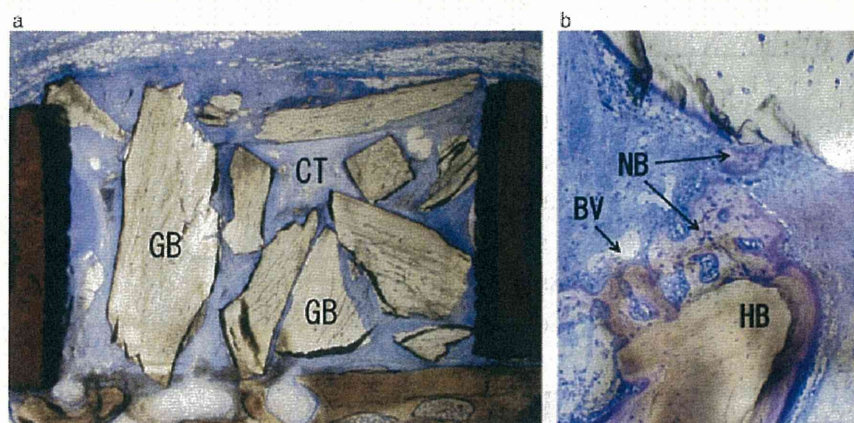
Large bone grafted site at 2 weeks. (a) Grafted bone (GB) almost preserved its original shape. In the interspace of the GB, fibrous connective tissue (CT) was observed. Magnification $\times 2.5$. (b) High-magnification image of (a). In the region close to the host bone (HB), blood vessels (BV) were found, and new bone (NB) formation occurred from the host bone surface to the GB surface. Magnification $\times 25$.
